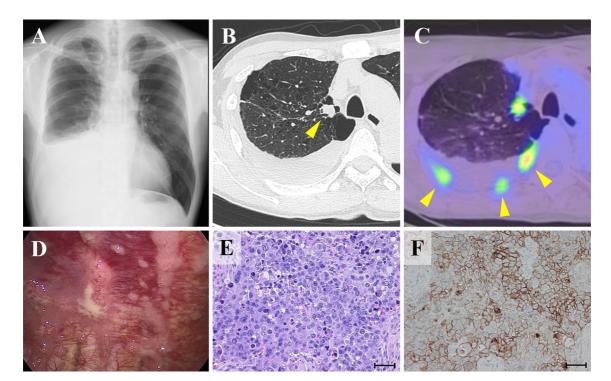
Findings at the diagnosis. Chest radiography shows right pleural effusion (A). CT and PET/CT show a primary lesion 12 mm in size on the right upper lobe of the patient's lung, pleural effusion, and multiple pleural thickening of the right (B, C, arrowheads). Thoracoscopy reveals multiple pleural nodules (D), and a biopsy of this area reveals poorly differentiated carcinoma (E). The tumor proportion score for PD-L1 expression (Dako 22C3 antibody) is 80-90% (F). Bars indicate 50 μ m.
